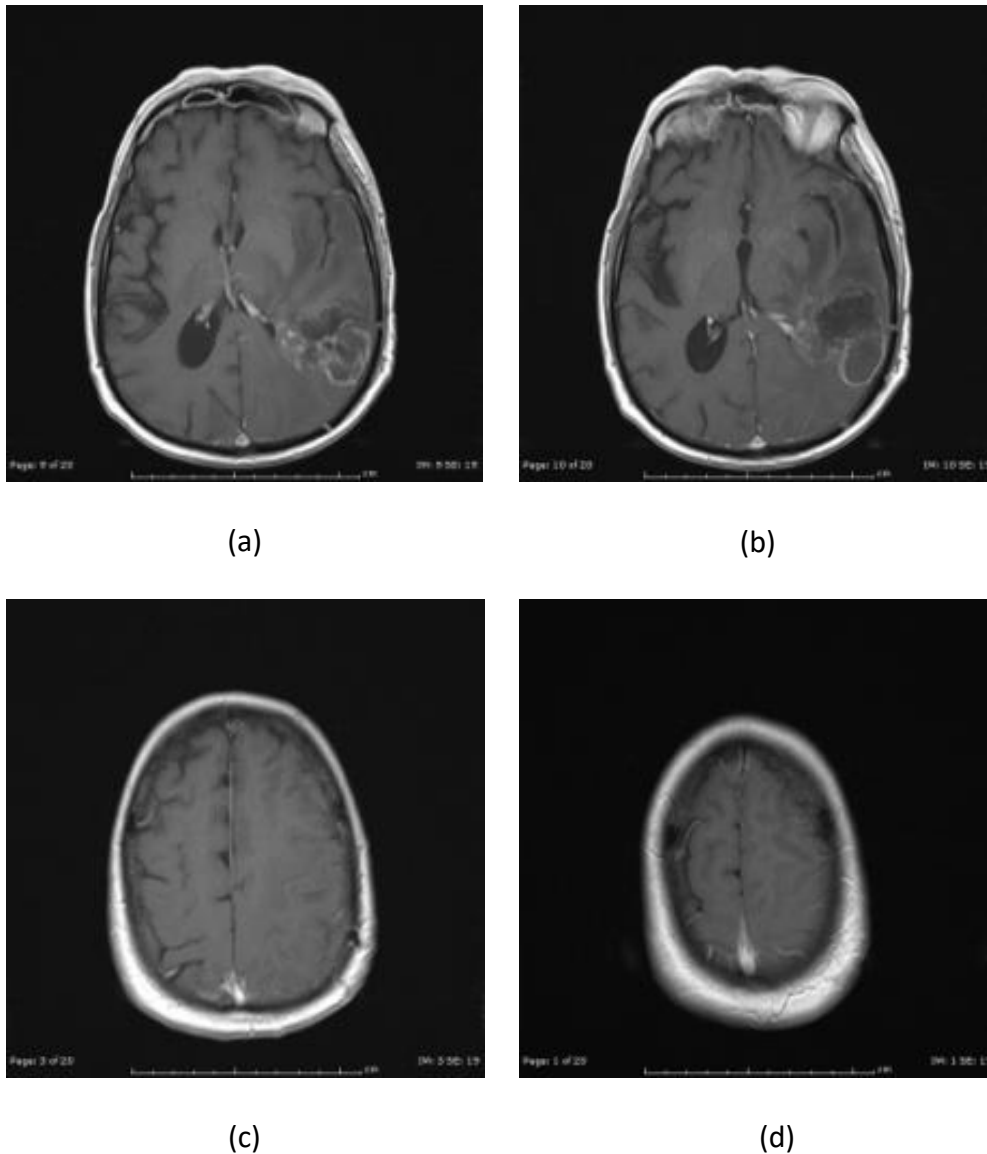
Sample of brain MRI Images from RGCI&RC: (a-b) abnormal brain;
